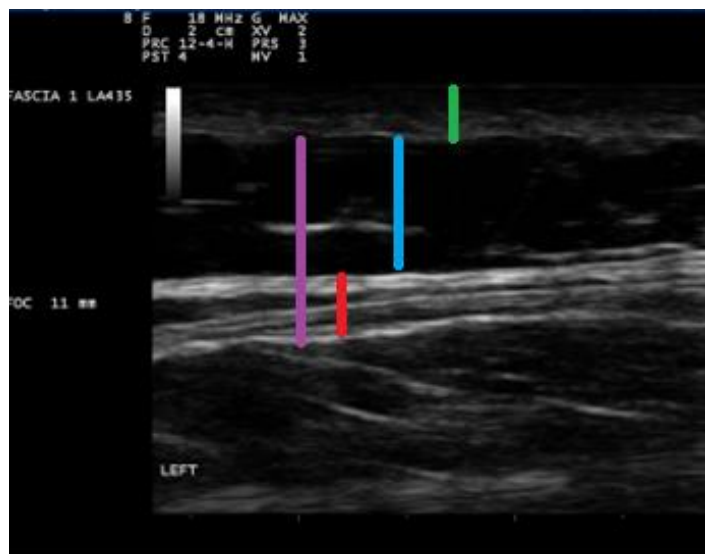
Ultrasound image of the thoracolumbar fascia of a participant with LBP.
